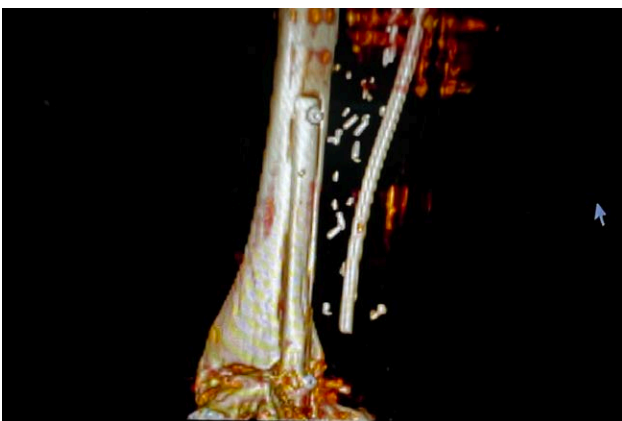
Case 4. Postoperative three-dimensional CT scan demonstrates placement of the fibula flap in the bone slot for ankylosis.
